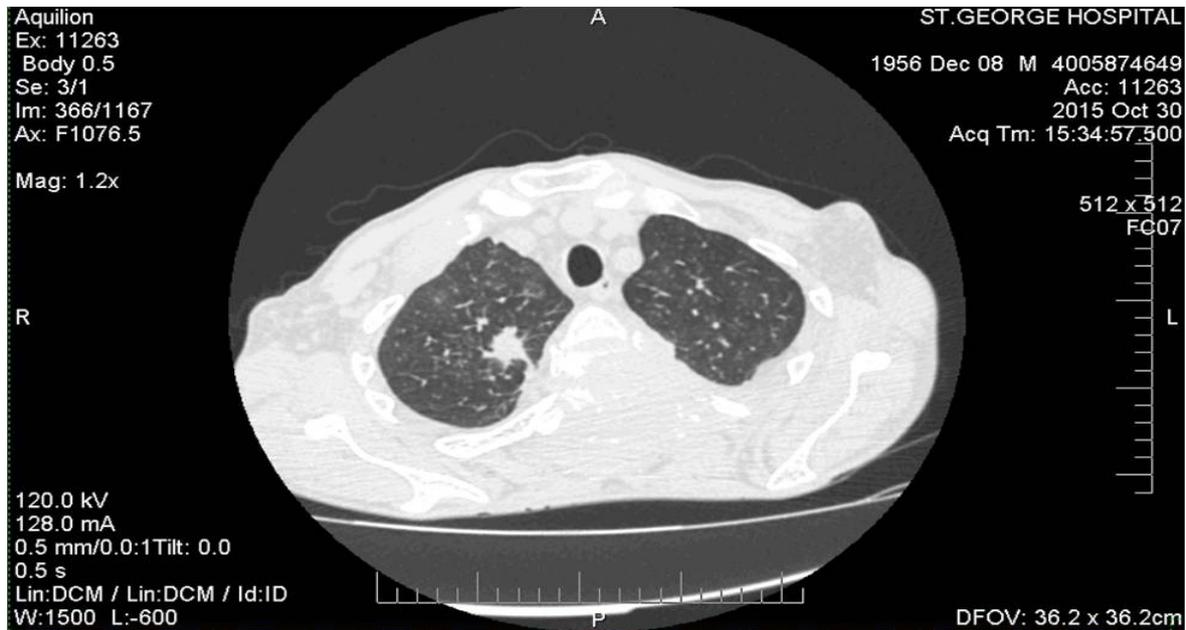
Chest computed tomography scan. CT scanning demonstrates in the upper lobe of the right lung spiculated nodule implicating mediastinal pleura.
